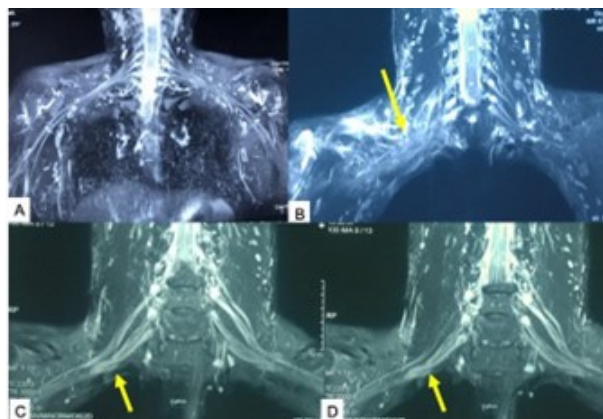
MRI of brachial plexus (BP): (A) normal MRI of BP; (B) MRI of BP with right-sided pan-brachial plexus injury; and (C,D) MRI showing right-sided middle and inferior trunks of BP injury. Arrow indicates injury site. Source: Figure by authors.
